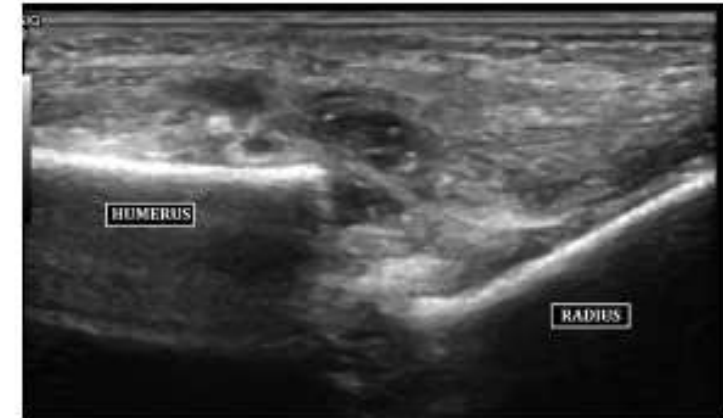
High frequency ultrasound examination of the affected elbow showing separation of the base of distal humeral epiphysis from the humeral metaphysis and bare surface of metaphysis without epiphyseal coverage.
